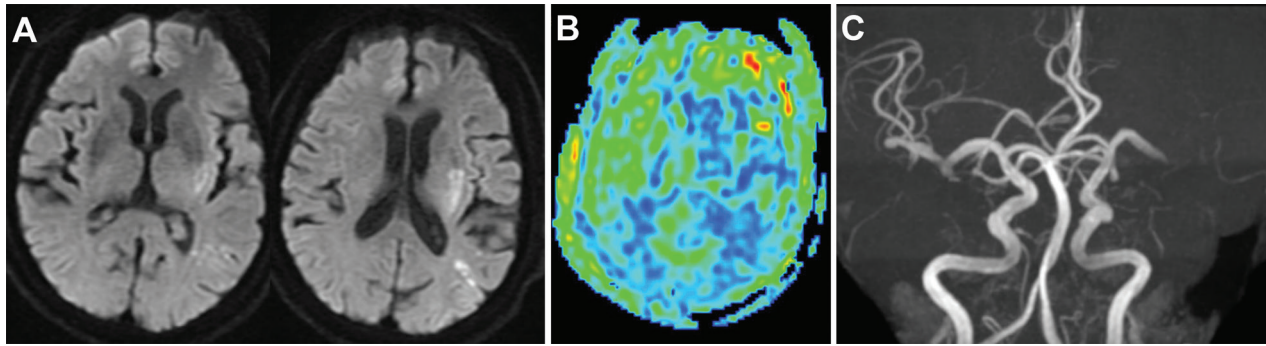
Case 1. Preoperative MRI-DWI (A)/ASL (B)/MRA (C). (A) A hyperintensity area was detected in the left cerebral hemisphere (DWI-ASPECTS: 8). (B) There was a reduction in blood flow in the left cerebral hemisphere. (C) Left M1 occlusion was observed. ASL: arterial spin labeling; ASPECTS: Alberta Stroke Program Early CT Score; DWI: diffusion-weighted imaging; MRA: magnetic resonance angiography; MRI: magnetic resonance imaging
